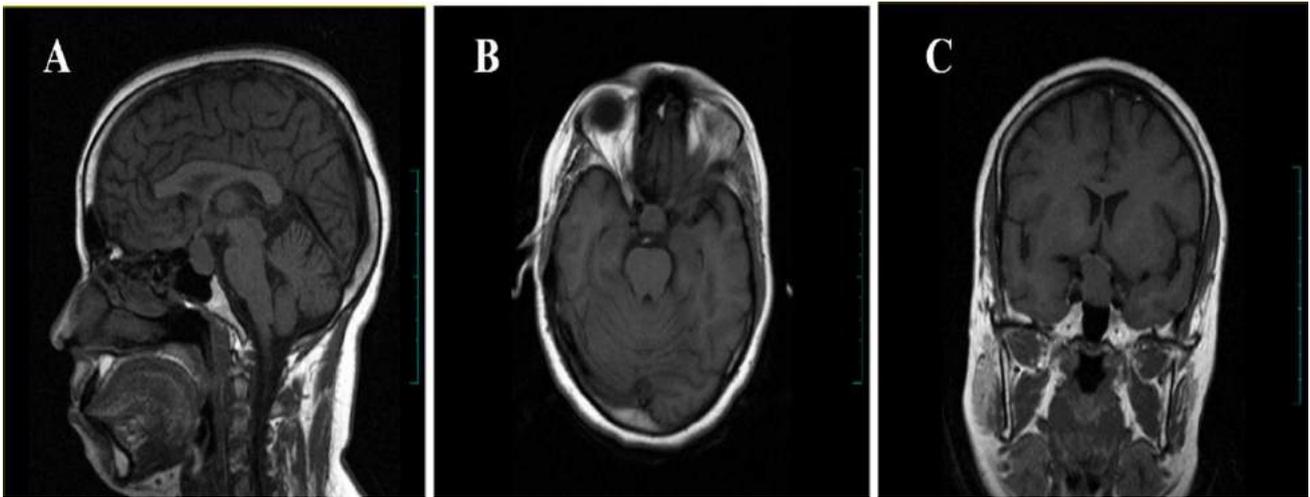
MRI BRAIN - T1 Images: A - Sagittal View, B - Axial View and C - Coronal View showing well defined isointense lesion in the pituitary fossa
